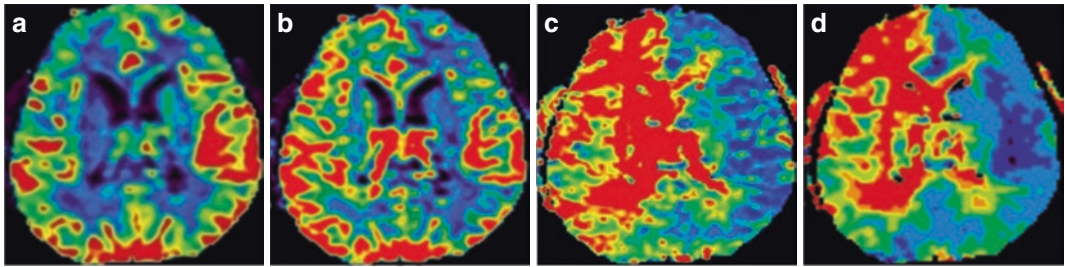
Right internal carotid artery occlusion. A 63-year-old male patient whose MRI shows bilateral periventricular lacunar infarction. Transverse PWI shows roughly symmetric CBF between the bilateral cerebral
